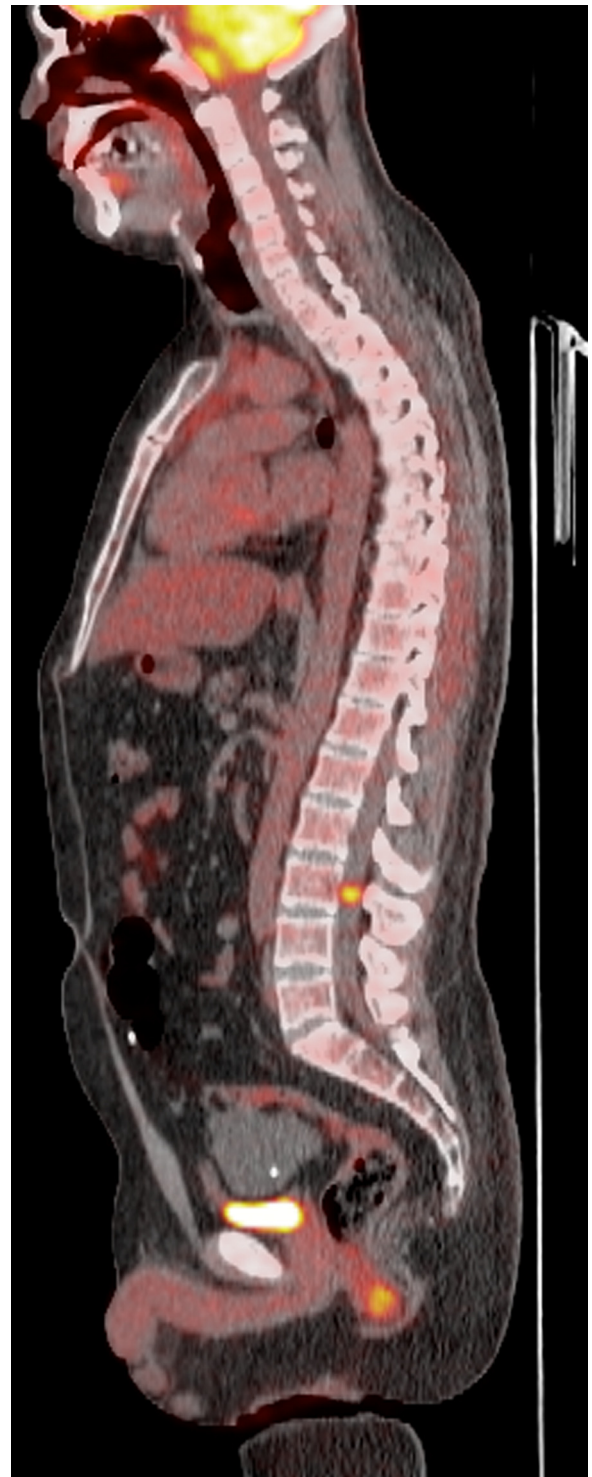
FDG-PET examination (sagittal multiplanar reconstruction, MPR) from October 2019 showing the radio tracer uptake only in the retroclival region and in the intraspedal space at the L3 level.
